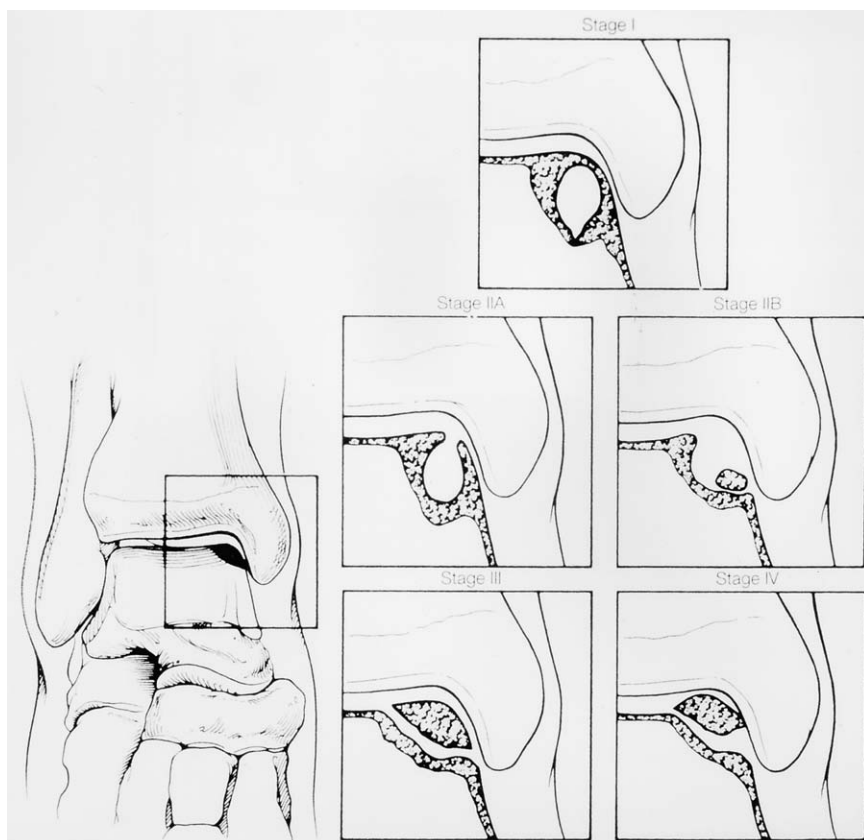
Classification system for OLT based on computed tomography. (From Ferrel RD. Arthroscopic surgery: the foot and ankle. Philadelphia: Lippincott-Raven, 1996; with permission.)
